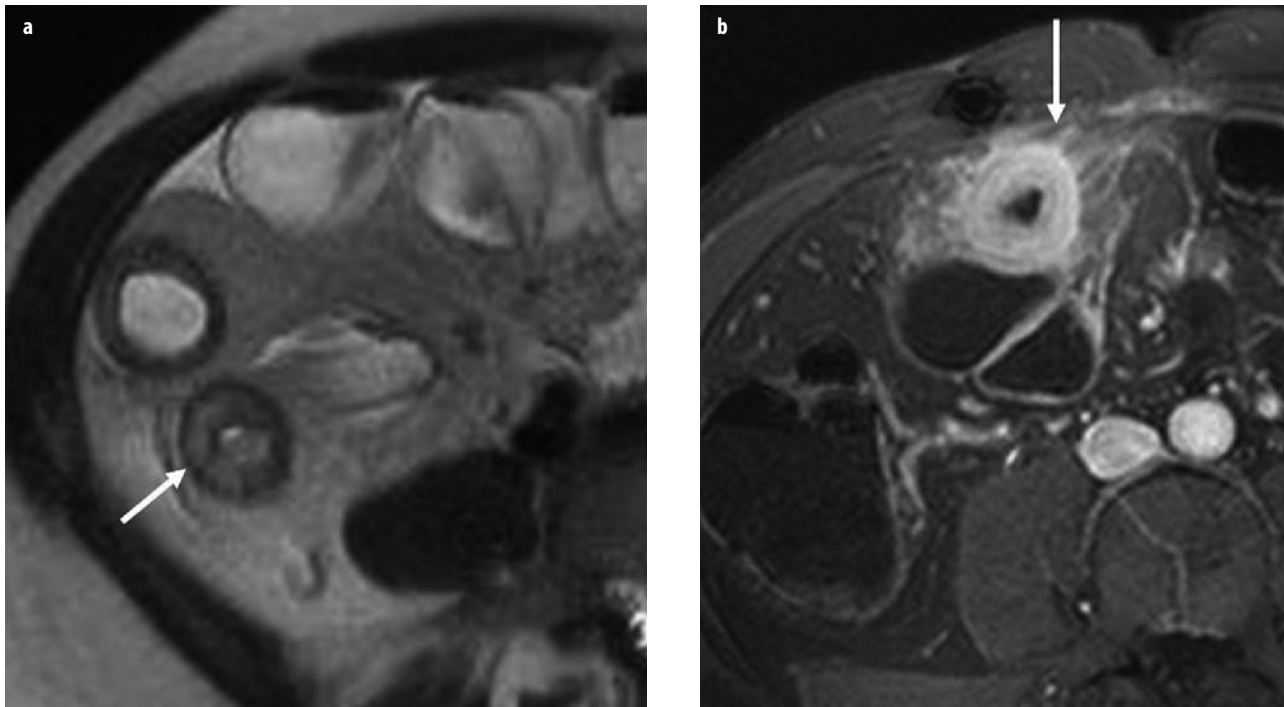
a, b. Active Crohn's disease: magnetic resonance (MR) enteroclysis. a T2-weighted axial single-shot turbo spin-echo (SSH-TSE) and b T1-weighted postgadolinium (Gd) contrast gradient echo (GRE) with fat saturation following biphasic intraluminal contrast administration (methylcellulose). A segment of small bowel in the right lower quadrant demonstrates significant wall thickening and submucosal edema, indicated by a hyperintense layer within the intestinal wall (a arrow). There is marked transmurial enhancement of the respective loop with even peri-intestinal involvement (b arrow). These signs are indicators of active Crohn's disease
